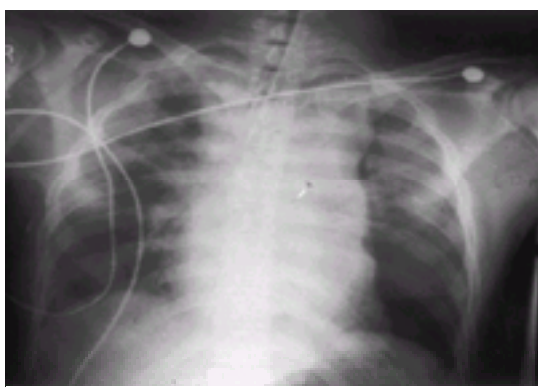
The plain chest radiograph in blunt aortic rupture.
